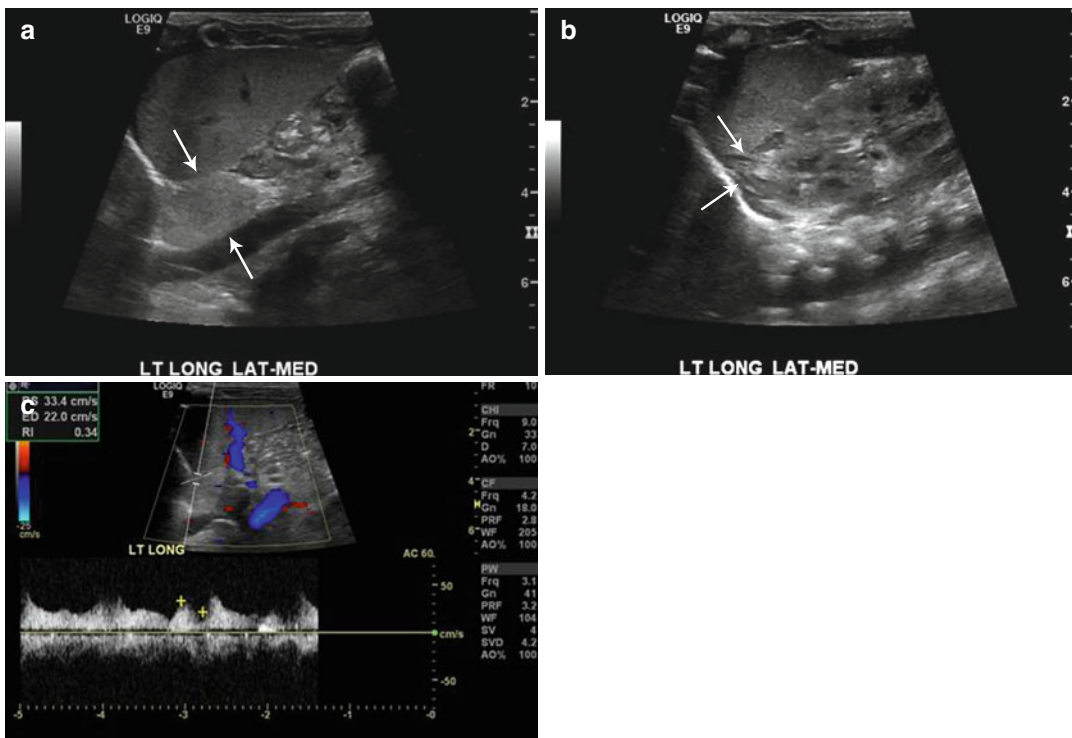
Retroperitoneal extralobar pulmonary sequestration. Longitudinal ultrasound images of the left upper abdomen (a) in an 11-day-old boy with prenatally diagnosed mass reveal an echogenic mass medially
